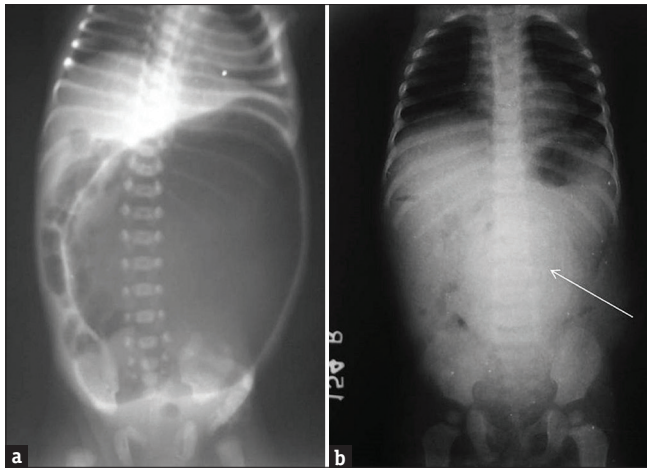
(a) Abdominal X-ray in a newborn girl with Type II congenital pouch colon showing a large left-sided abdominal gas shadow. Note the normal sacrum. (b) Abdominal X-ray in a 2-year-old girl with Type I congenital pouch colon showing a large radio-opacity on the left side of a distended abdomen due to inspissated, accumulated fecal matter (arrow)
